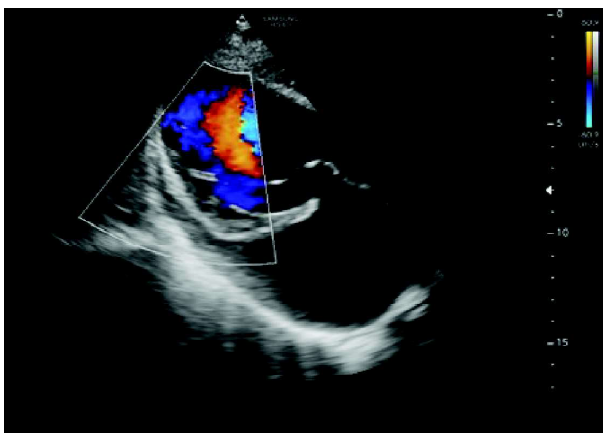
Echocardiography showing blood flow into intertrabecular recesses of RV.
